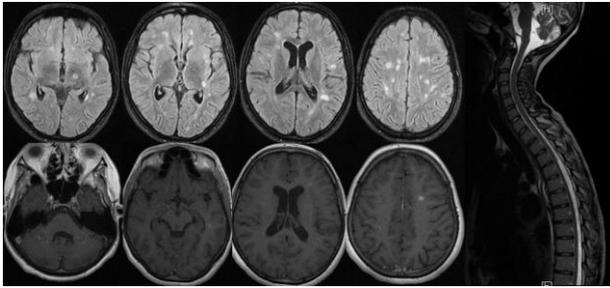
Brain and spinal cord MRI after 2 months, showing an increase in the number and volume of the lesions.
